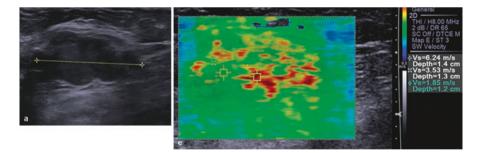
Elastography showing that the solid macrolobulated mass seen on gray-scale ultrasound (*left image*) has high velocities highly suspicious for malignancy (*right image*). Biopsy confirmed invasive ductal carcinoma (Reprinted with permission from Ref. [80], Richard G. Barr, Breast Elastography. Thieme Publishers Inc. 2014)
